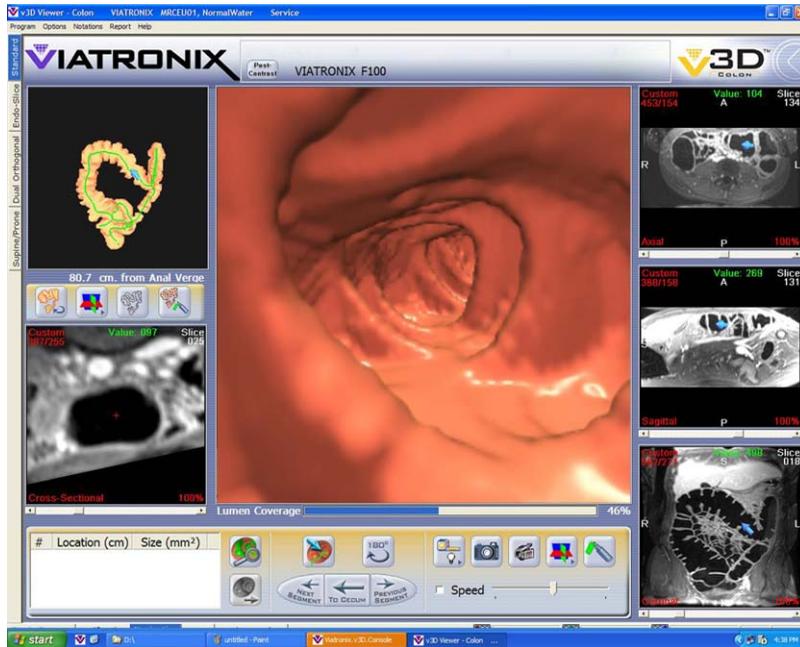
Software platform for the evaluation of MR colonography. The T1-weighted data sets are displayed simultaneously in different manners: a virtual endoscopic view, the coronal source data, and axial and sagittal reconstructions are shown (Viatronix, Stony Brook, NY).
